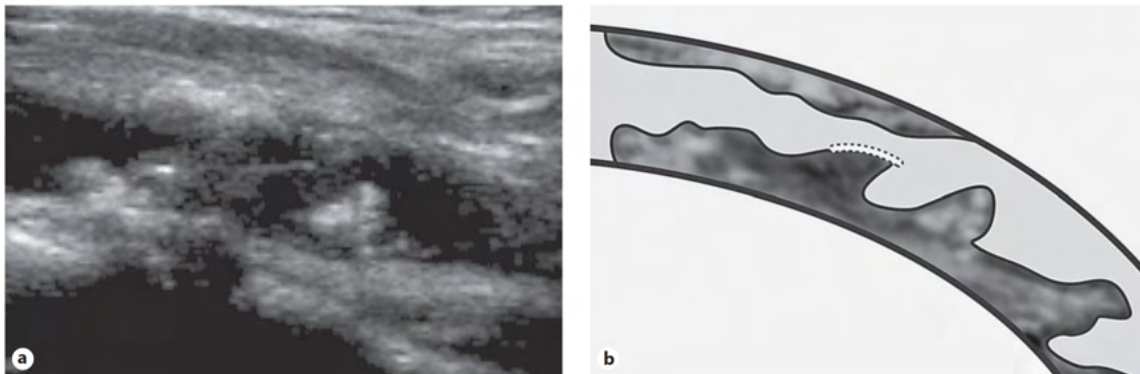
Jellyfish-type plaque seen by supra-aortic trunk ultrasound (A) and its scheme (B) (36).
